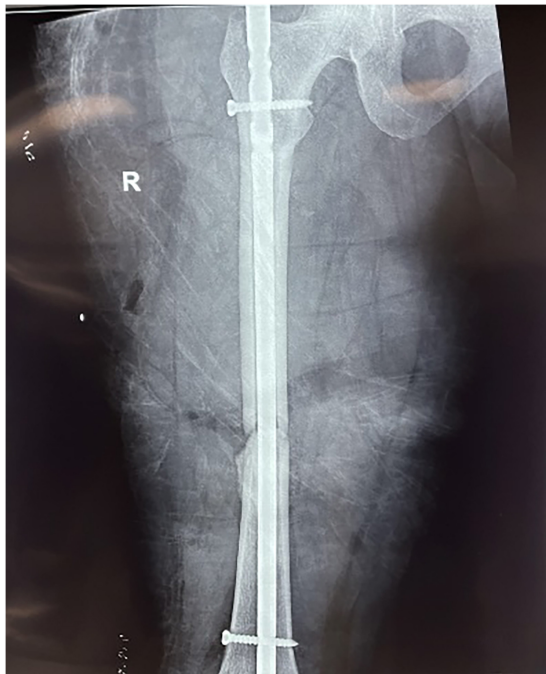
X-ray femur antero-posterior view showing post-fixation of femur shaft fracture reduced with intramedullary interlocking nail in situ.
